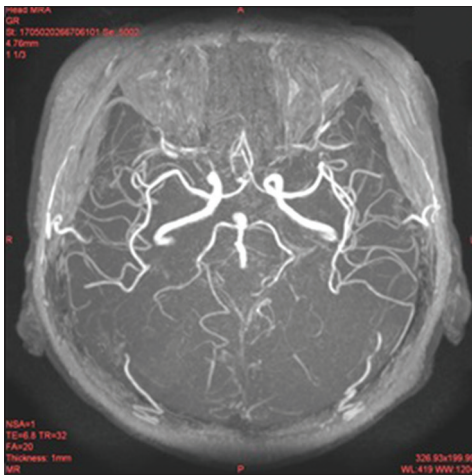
Magnetic resonance imaging angiography of the brain on April 12, 2017, showing a basilar tip saccular aneurysm
